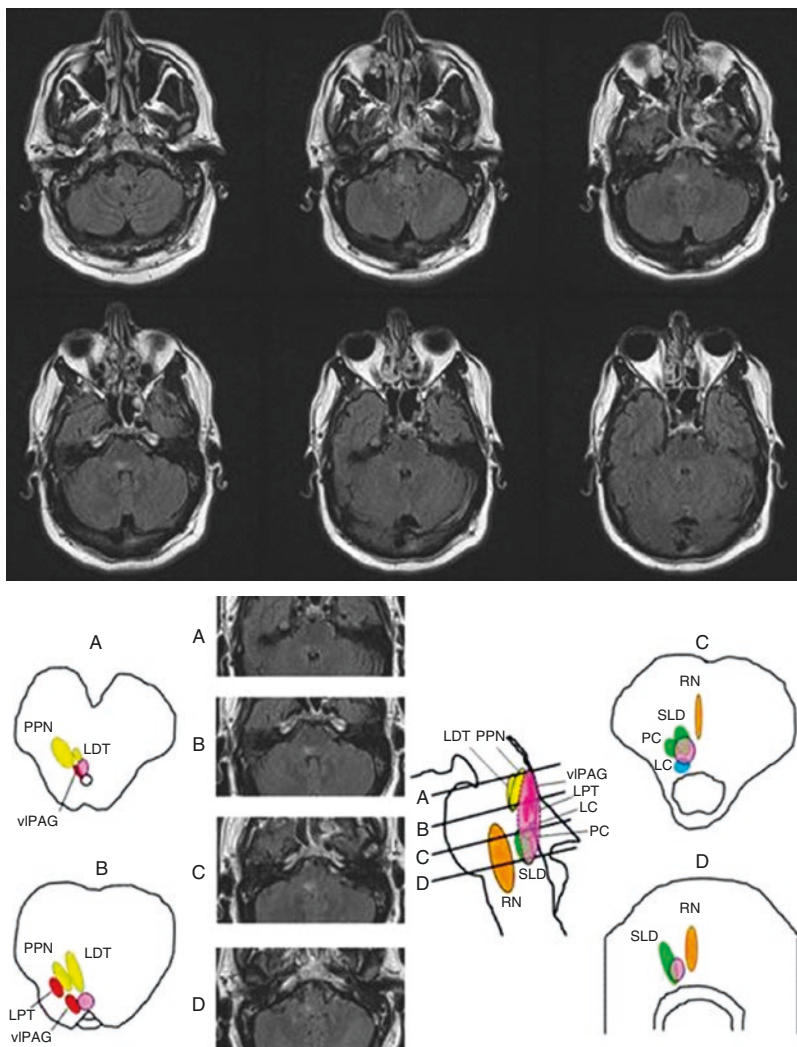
Lesional RBD in the dorsal pontomedullary junction resulting from CNS vasculitis. Top panel. Coronal FLAIR intensity MRI sections at the level of the medulla and pons, showing a discrete longitudinally extensive hyperintense lesion at the level of the dorsomedial pons extending rostrally to the right superior pons ventral to the superior cerebellar peduncle. Bottom panel. The brainstem nuclei thought to be involved in REM sleep atonia regulation are shown on human brainstem templates. Letters for each template and corresponding MRI FLAIR image sections selected from our case represent cross-sectional views through the brainstem as shown in the midsagittal figure, with sections representing (A) the pontomesencephalic junction, (B) the upper/mid-pons, (C) the lower/mid-pons, and (D) the pontomedullary junction. The approximate location of the lesion is shown in the superimposed pink oval. *VLPAG* ventrolateral periaqueductal gray, *LC* locus coeruleus, *LDT* laterodorsal tegmental nucleus, *LPT* lateral pontine tegmentum, *PC* precoeruleus, *PPN* pedunculopontine nucleus, *REM* rapid eye movement, *RN* raphe nucleus, *SLD* sublateralodorsal nucleus, *viPAG* ventrolateral part of the periaqueductal gray matter. As modified from Boeve BF, Silber MH, Saper C, et al. Pathophysiology of REM sleep behavior disorder and relevance to neurodegenerative disease. *Brain* 2007;130:2770–2788. Reprinted with permission from St. Louis EK, McCarter SJ, Boeve BF, Kantarci K, Rando A, Silber MH, Olson EJ, Tippmann-Peikert M, Mauerma M. REM sleep behavior disorder localizes to the dorsomedial pons. *Neurology* 2014;83(20):1871–3
